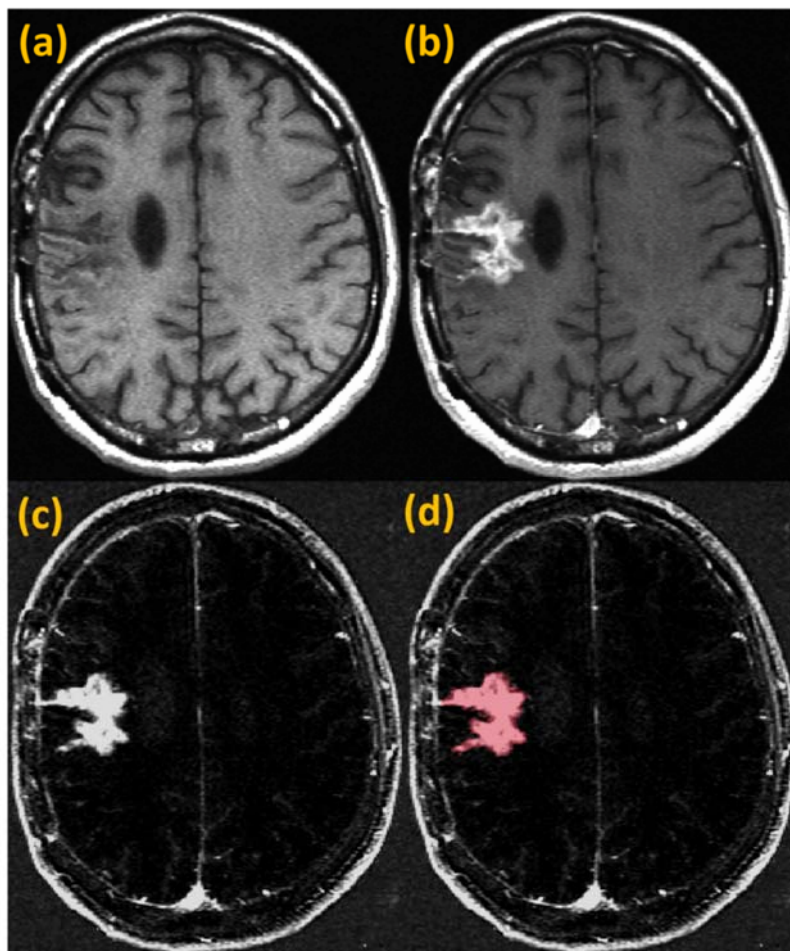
Analysis of functional neuroimages (AFNI). (a) T1 weighted MRI scan image. (b) Contrast material-enhanced T1 weighted MRI scan image at the same location of (a). (c) Image subtraction between (a) and (b). Only the enhanced region visualized and highlighted a tumor lesion. (d) Selected ROI for the volume estimation with the AFNI program. Each pixel in an image has a designated volume depending on MRI scan conditions. Multiple MRI scans will be integrated into tumor volumes (mm^3).
